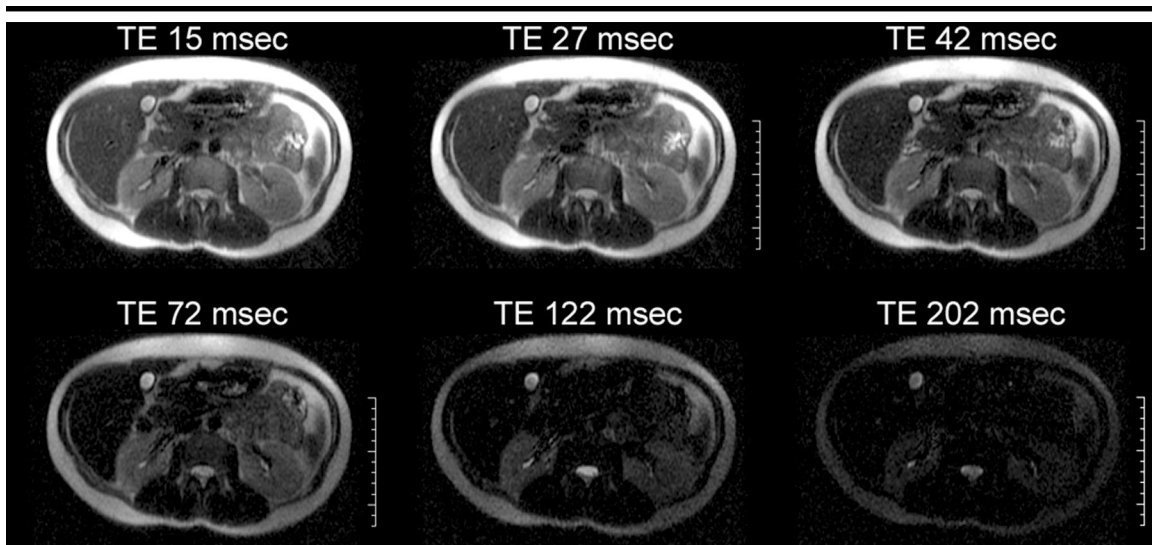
(a) Transverse MR images obtained through the level of the kidney at 3.0 T with a half-Fourier acquisition single-shot fast SE sequence combined with SE preparation (field of view, 360 × 252; section thickness, 5 mm; acquisition matrix, 256 × 160; effective TE, 60 msec). Six preparation TEs (15, 27, 42, 72, 122, and 202 msec) were used to measure the T2 relaxation time with a constant TR of 2,000 msec. With a short T2 relaxation time (37 msec), the signal decayed more rapidly in the liver than in fat, which exhibited a longer T2 relaxation time (66 msec). The scale is in centimeters. (b) Signal intensities in the ROIs as a function of SE preparation time and TI, as measured in the images in a. Fitted curves are shown as continuous lines through the data points and were used to measure T2 relaxation time.
